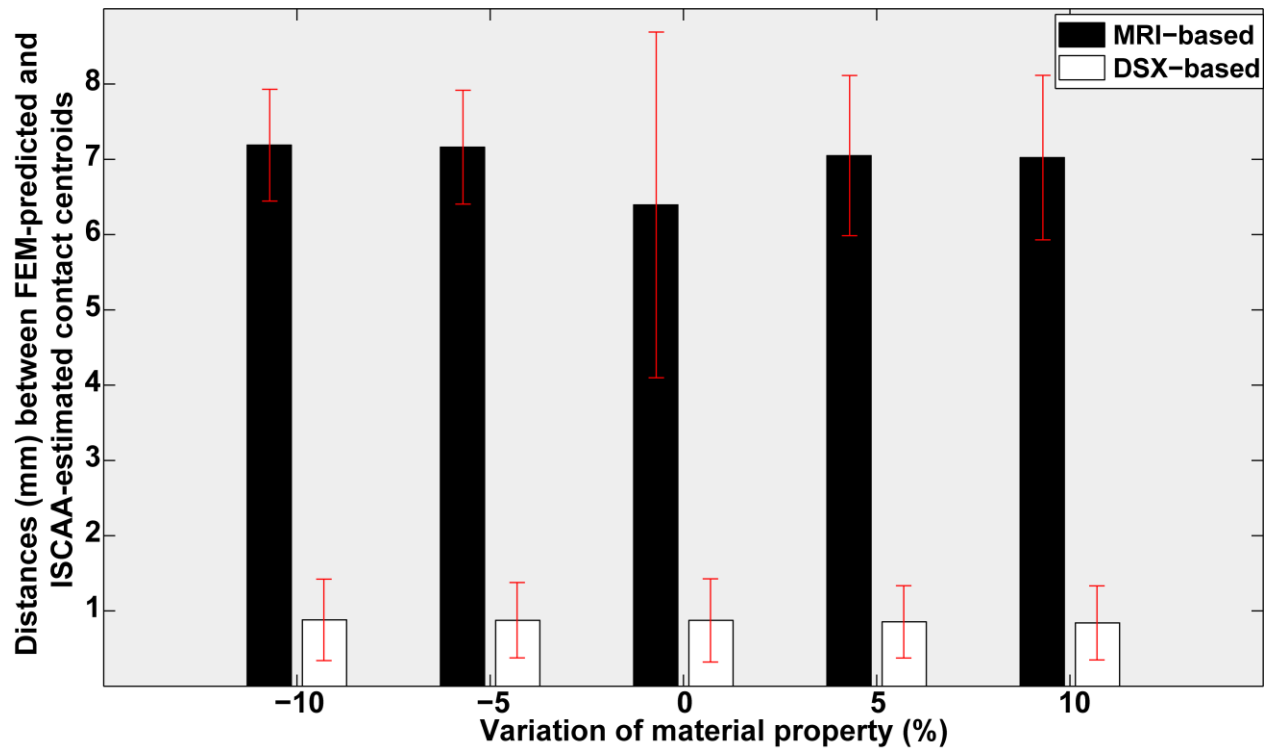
Average distances between FE-predicted and ISCAA-estimated contact centroids at different levels of material property variation for both MRI-based and DSX-based models.
